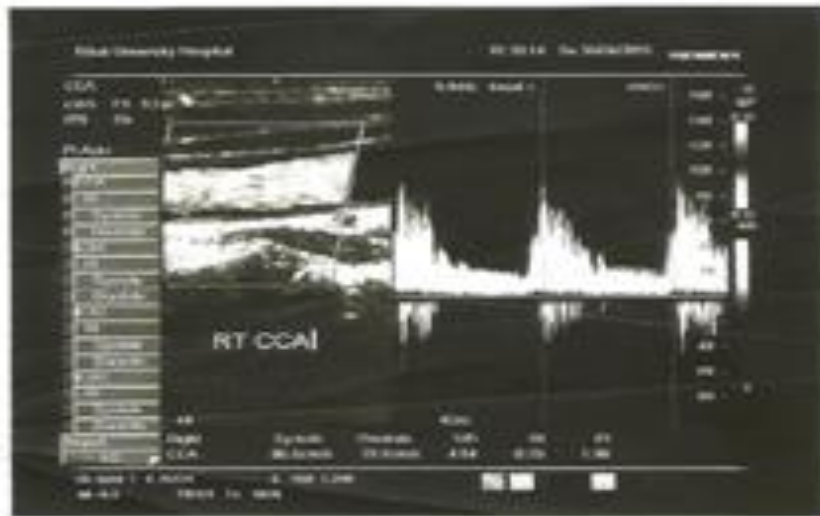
Rt CCA-female- 52 years diabetic patient with normal Doppler parameters.
